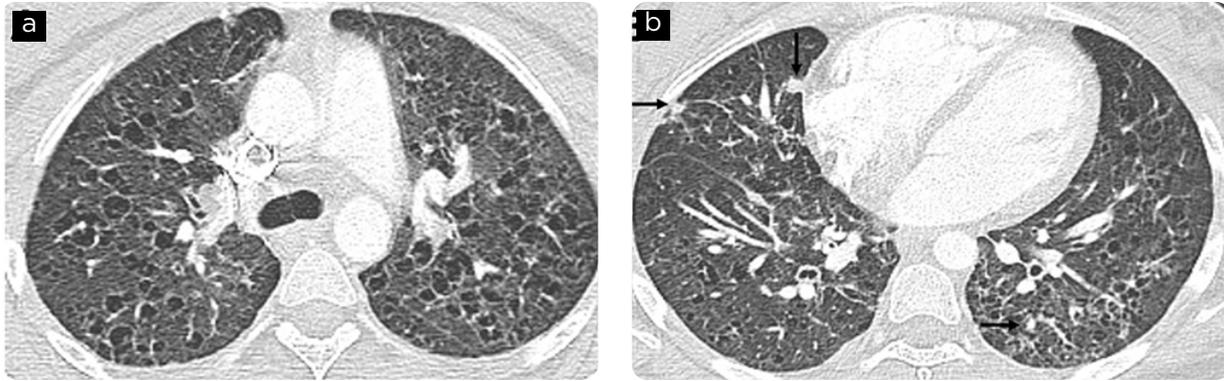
Patient with tuberous sclerosis and progressive respiratory symptoms. Chest CT, lung window. a) Axial section in upper lobes, b) axial section in lower lobes. Multiple areas of cystic appearance and thin wall in the four quadrants suggestive of lymphangioleiomyomatosis. There are some small nodules of random distribution (arrows).
